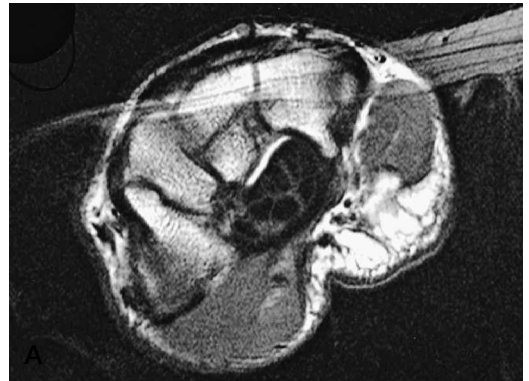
Axial T1-weighted (A) and inversion recovery (B) MR images show an undisplaced fracture in the capitate bone that divides the bone into a ventral and a dorsal portion.
